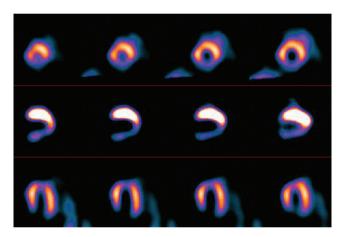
Poor quality of the <sup>123</sup>I-mIBG SPECT, low uptake in inferior wall of left ventricle
